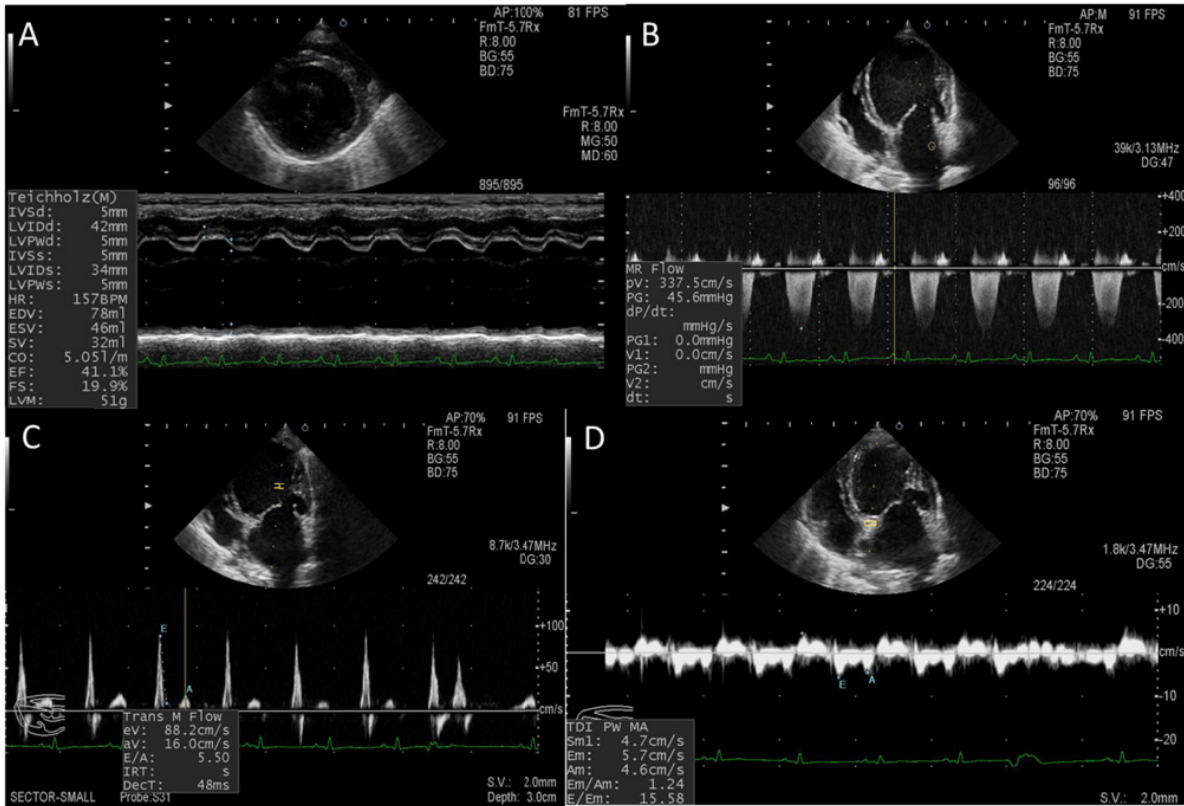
Transventricular time-motion echocardiogram (A), spectral Doppler (B, C), and tissue Doppler imaging (D) of the patient. Doppler imaging was taken from the left apical four-chamber view. (A, B) Low shortening fraction (19.9%) and mitral regurgitation velocity (5.96 m/s) were identified. (C) Early diastolic mitral inflow velocity (0.88 m/s) was increased with an E:A ratio of 5.5 and a short E-wave deceleration time (48 ms). (D) Tissue Doppler imaging in LVW showing no reversal E'A'.
